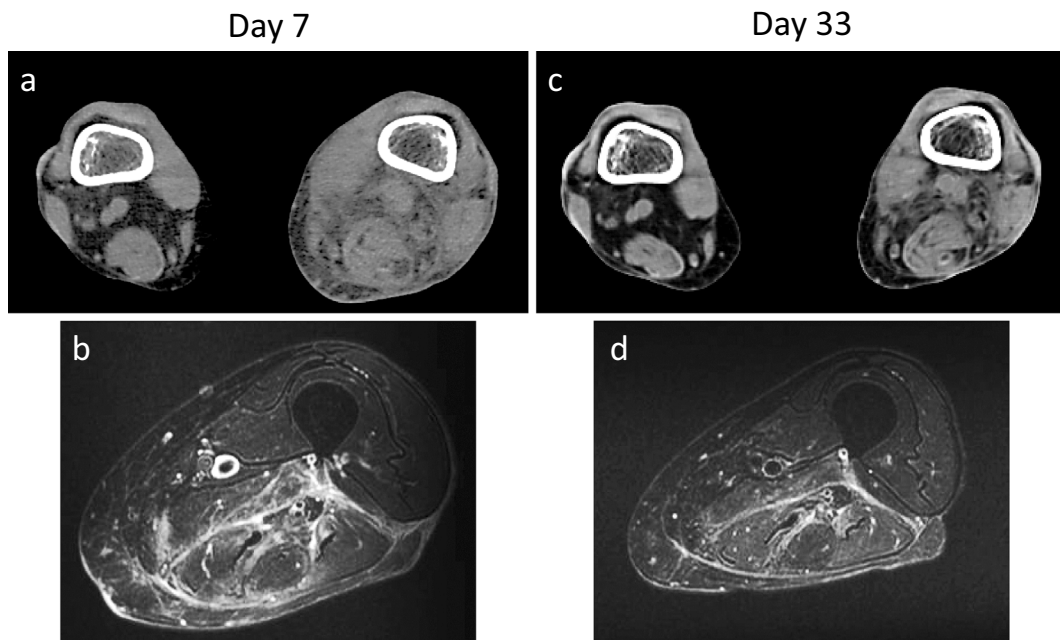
Computed tomography (CT) (a, c) and fat-suppressed T2-weighted magnetic resonance imaging (MRI) (b, d) of the legs. The CT scan revealed soft tissue inflammation in the left leg with no aerogenic findings (a). Left femoral myofascial inflammation was observed on the MRI scan (b).
